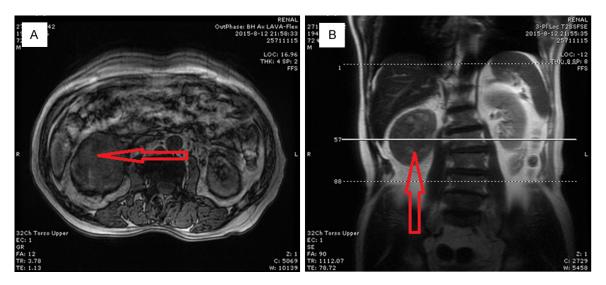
Abdominal MRI revealed a giant mass (7.2×6.3×5.6 cm³) of mixed intensity (red arrows), with poorly-demarcated margins that protruded towards the right renal vein and inferior vena cavain axial view (A) and sagittal view (B). The right renal pelvis and superior segment of right ureter were also invaded.
